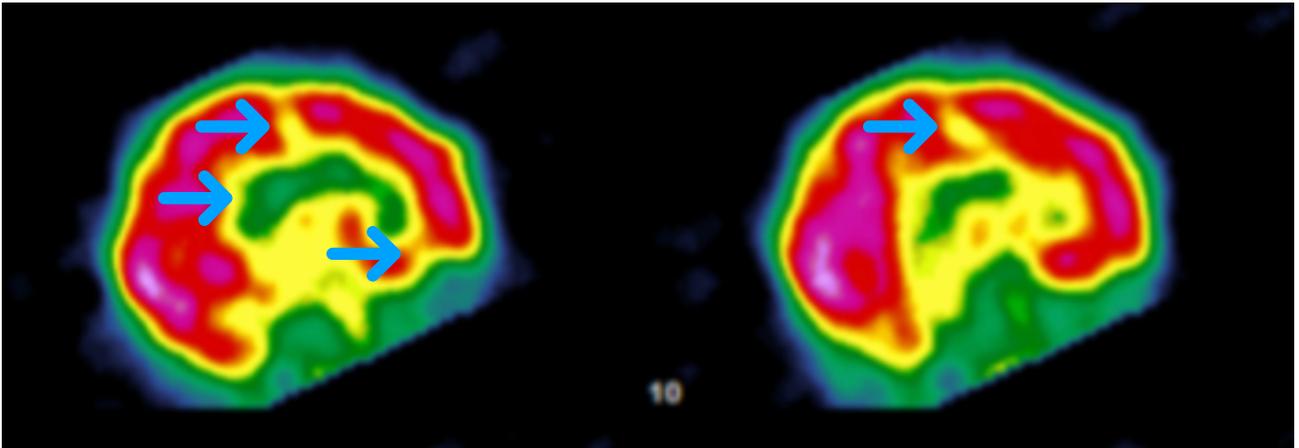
Single Photon Emission Computed Tomography brain flow imaging 3 days before (first picture), 3 days after 80 sessions of HBOT (middle picture) and 1 year after hyperbaric treatment (last picture). Note the local (arrows) and global increase of perfusion
